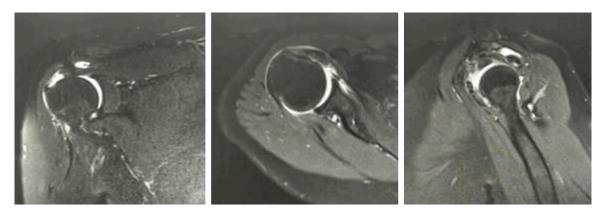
MRI of the right shoulder before surgery. The right supraspinatus tendon was torn and withdrawn slightly with local congestion. Longitudinal tears were seen in 2/3 of the subscapularis tendon, with no obvious retraction.
